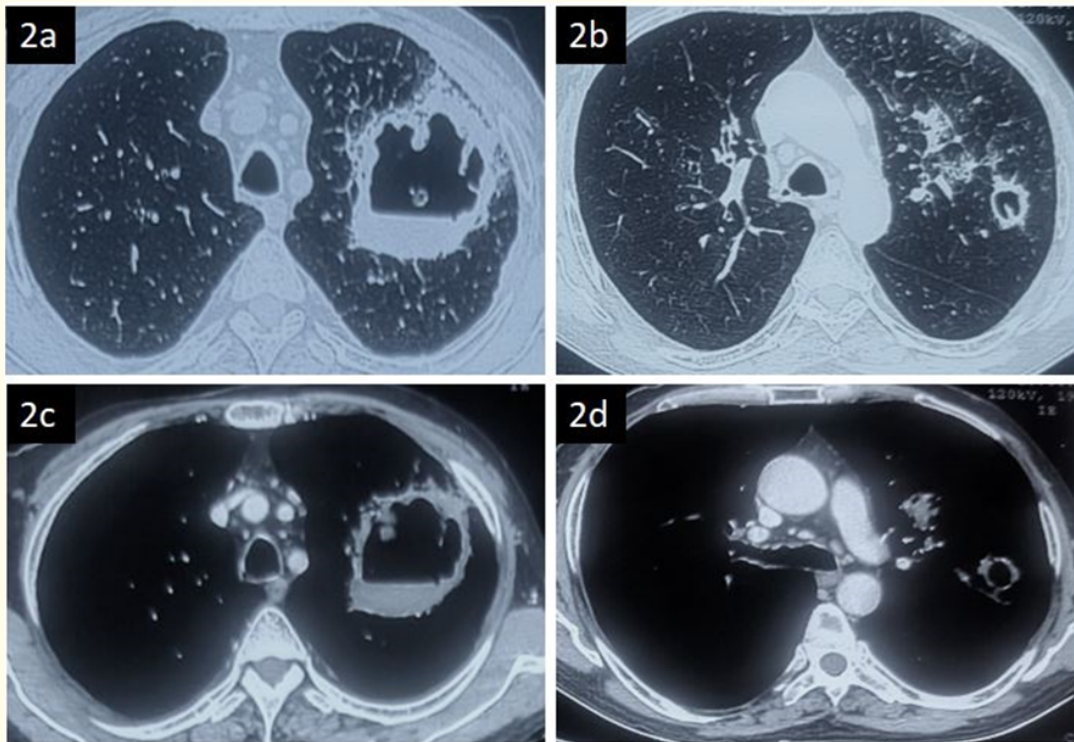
Computed tomography of chest: figure 2a and 2b - axial section of lung window; figure 2c and 2d -axial sections of mediastinal window at different levels of cross-section.
